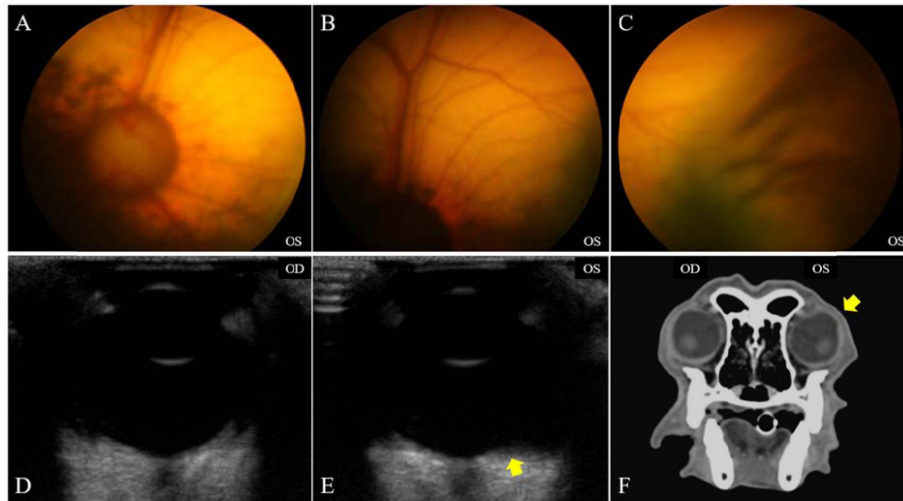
Fundus appearances and representative images of 10 MHz ocular ultrasonography and CT scanning. (A), (B) and (C) The left eye showed wrinkled retinal ingression at lateral fundus. The right eye showed normal fundus; (D) and (E) scleral ectasia in the left eye (arrow) was revealed on ultrasonogram; (F) The CT image also showed scleral ectasia in the left eye (arrow).
